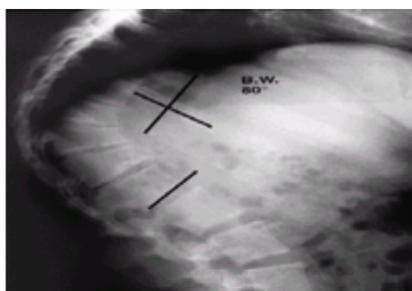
Lateral radiograph of a patient with Scheuermann disease demonstrates the kyphotic deformity seen in this disorder. Note the irregularity of the vertebral end plates and the anterior vertebral wedging.
